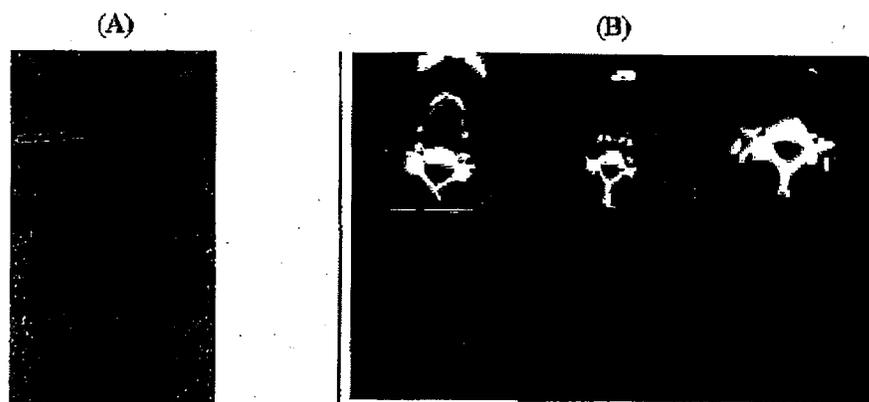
(A) The planar  $^{131}\text{I}$ -iodide scan in a 16 year old patient with thyroid cancer discloses an iodine-avid focus (arrow). The patient had had three surgical procedures (including total thyroidectomy) and 37 GBq of  $^{131}\text{I}$ , so that this focus indicates the presence of a further lymph node metastasis. Considering scarring from prior surgeries, exact localization of this lesion is an essential requisite for its surgical resection. This anatomic information can only be achieved by SPECT/CT (B).
